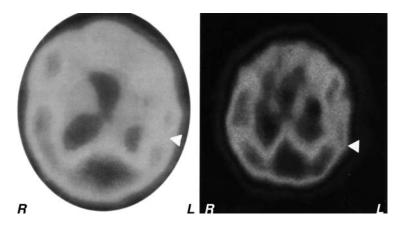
SPECT pre- (*left*) and post-cortical stimulation (*right*) showing renormalization of SI rCBF
